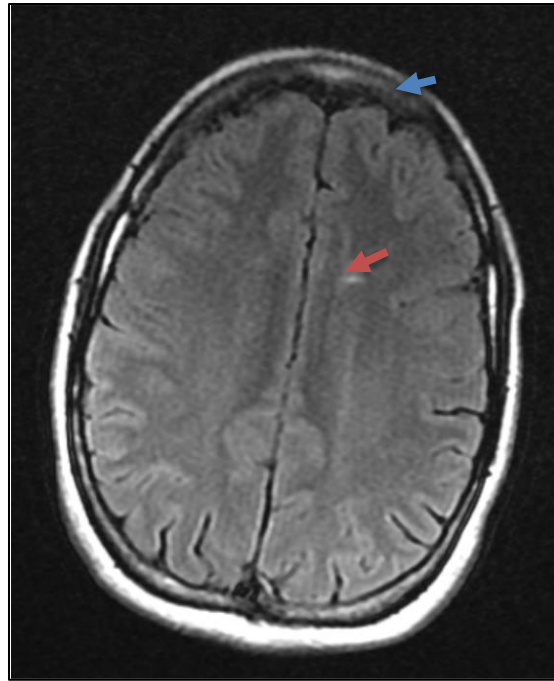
Axial FLAIR MRI showing hyperintense lesions in the left periventricular and subcortical white matter (orange arrow) with visualization of the linear subcutaneous plaque (blue arrow).
